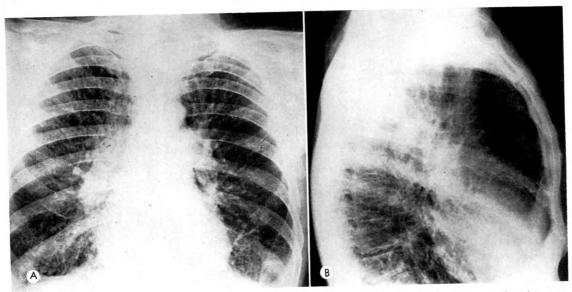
(A and B) Roentgenograms of a 60 year old white man with chronic cough and increasing dyspnea. Note that the thorax appears fixed in the inspiratory attitude, which implies that the mechanics of breath ing are greatly impaired. The lungs are overdistended, but very little air flows in and out with respiration. Note, also, the enlargement of the main pulmonary arteries which probably indicates pulmonary hypertension due to obliteration of many of the peripheral arterioles and capillaries.
